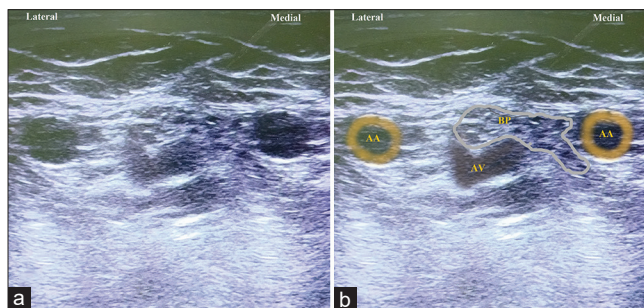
(a) Ultrasound imaging of the axillary region resembling an owl face (b) Labeled image of panel A, double axillary artery of equal caliber, equidistant from the axillary vein. Brachial plexus nerves appeared as a single mass, more toward the medial axillary artery
